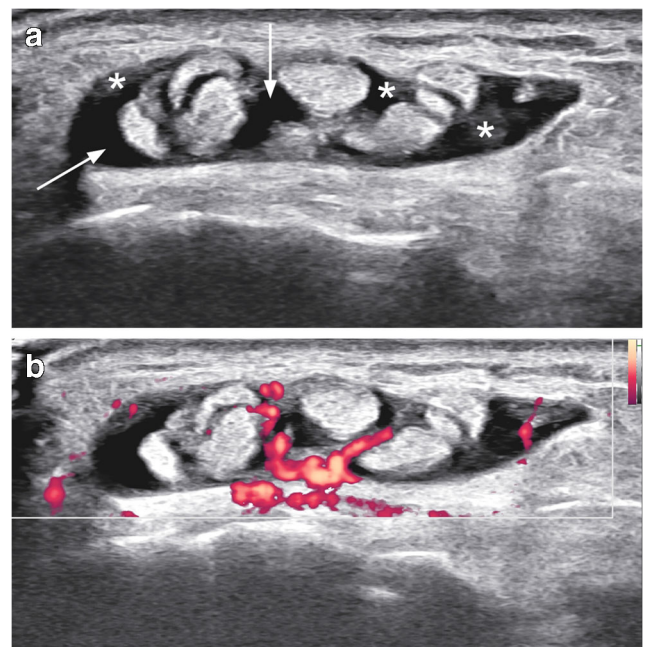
Power Doppler ultrasound appearance of EDCST in a 59-year-old male patient. a Transverse grayscale and b power Doppler ultrasounds obtained distal to the thickened ER. In a, note the normal hyperechoic tendons surrounded by an effusion (arrows) and hypoechoic thickening of the synovial sheath (asterisks). b Power Doppler shows hyperemia of the sheath
